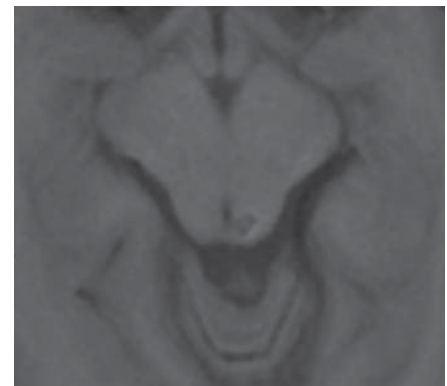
MRI of the brain on 11.02.2005, T2 GRE axial (TR 802, TE 29). Heavy signal loss in the left inferior tectal plate. No other lesion of this kind in the brain parenchyma.
